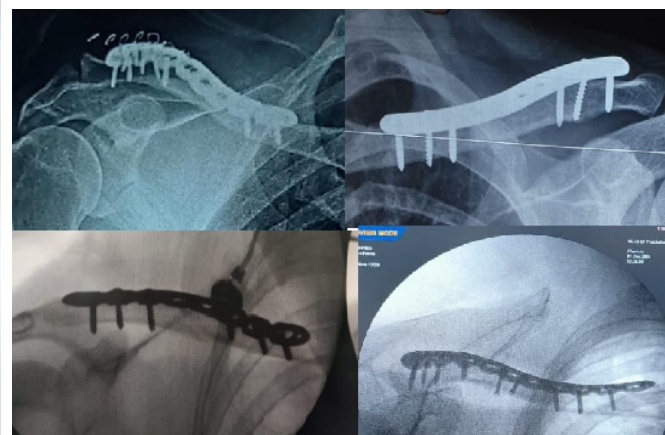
Immediate post-operative X-rays of patients in this study.
